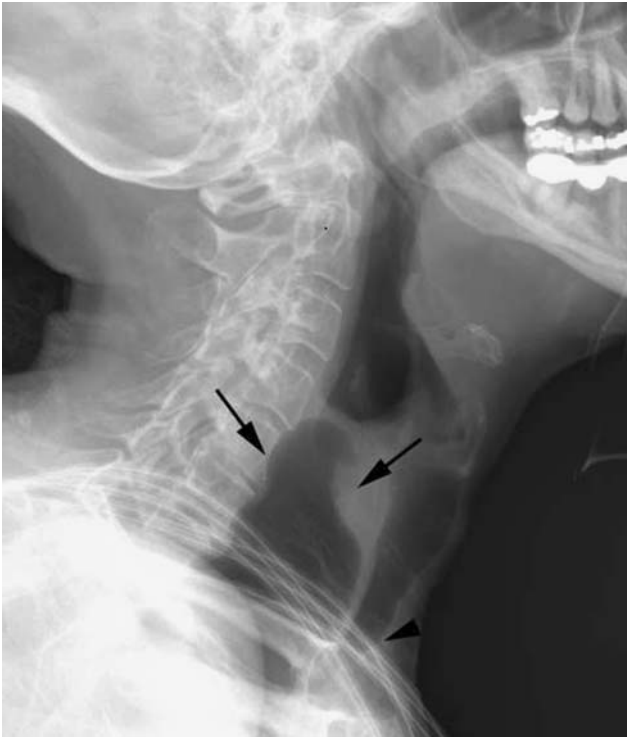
Lateral neck radiograph demonstrating a widely dilated upper esophagus (*arrows*) and tracheal compression (*arrowhead*)
